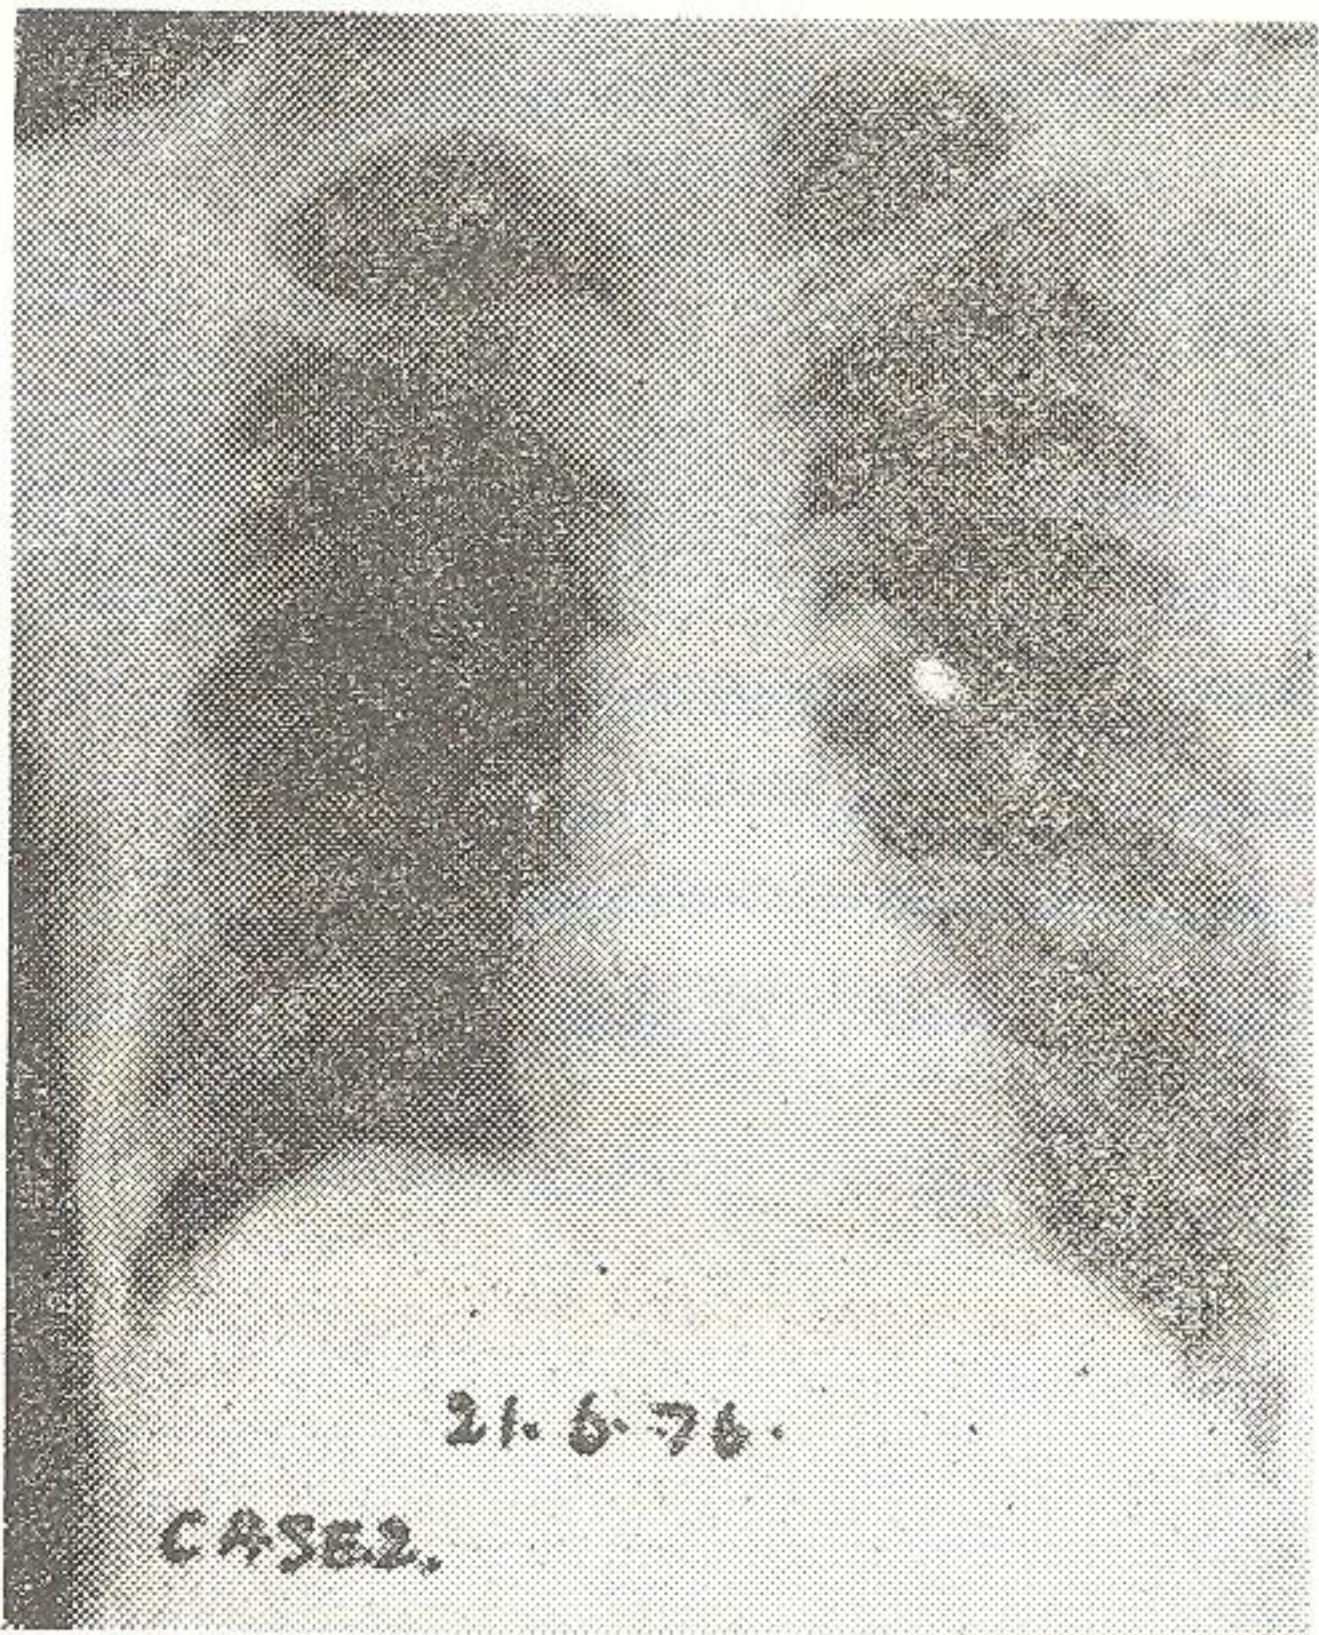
Case-2 (21-6-1976). X-Ray chest P.A. view showing no significant abnormality with minor tenting of right diaphragm.
